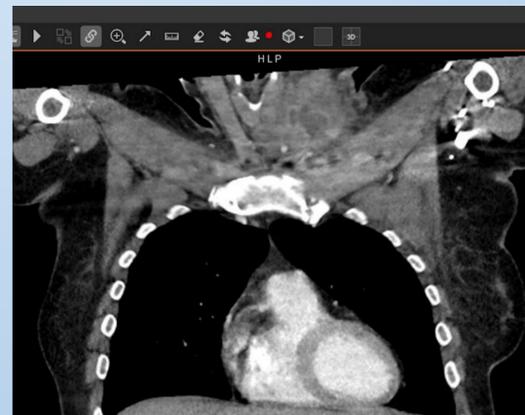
CT Soft Tissue Neck showing: 2 x 5.5 cm irregular rim enhancing collection consistent with residual abscess.
